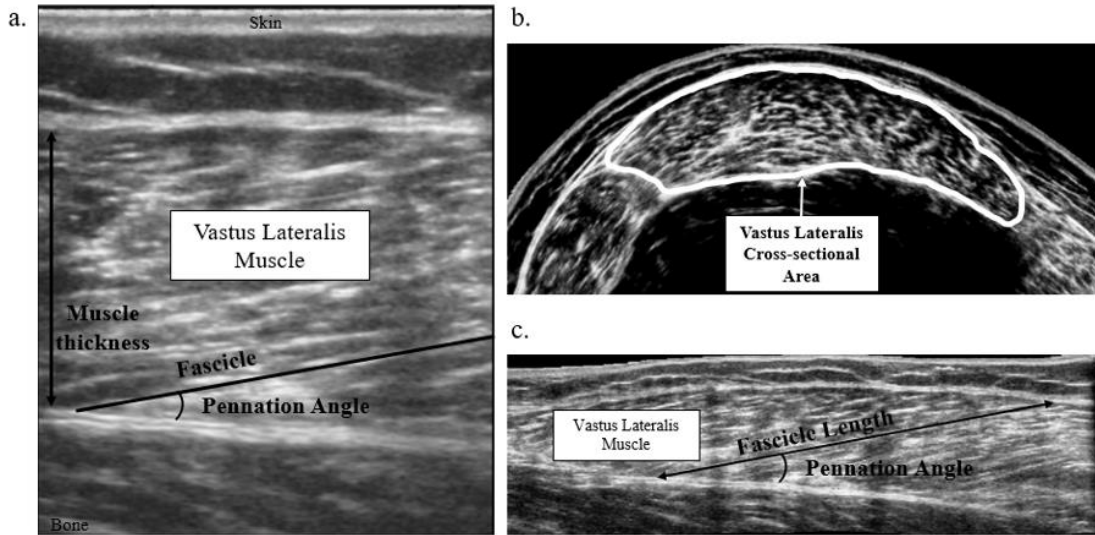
Ultrasonography images of the vastus lateralis muscle. a) static long-axis image identifying muscle thickness, fascicle, and pennation angle; b) extended-field-of-view short axis image identifying muscle anatomical cross-sectional area; c) extended-field-of-view long axis image identifying fascicle length and pennation angle.
